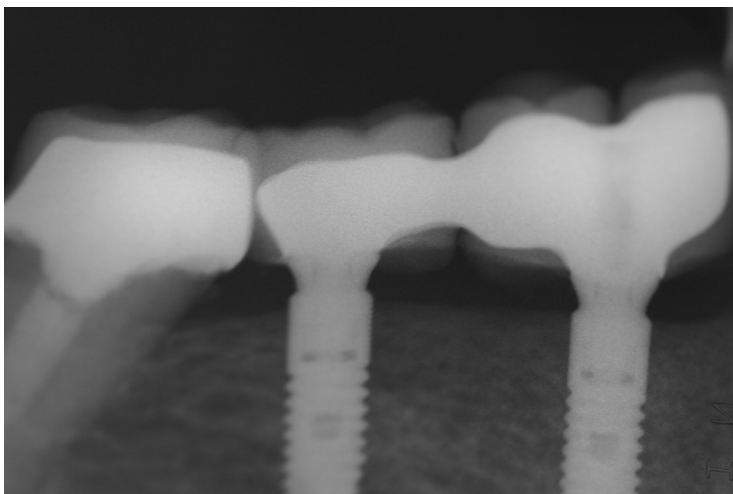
Radiographic control before cementation.
